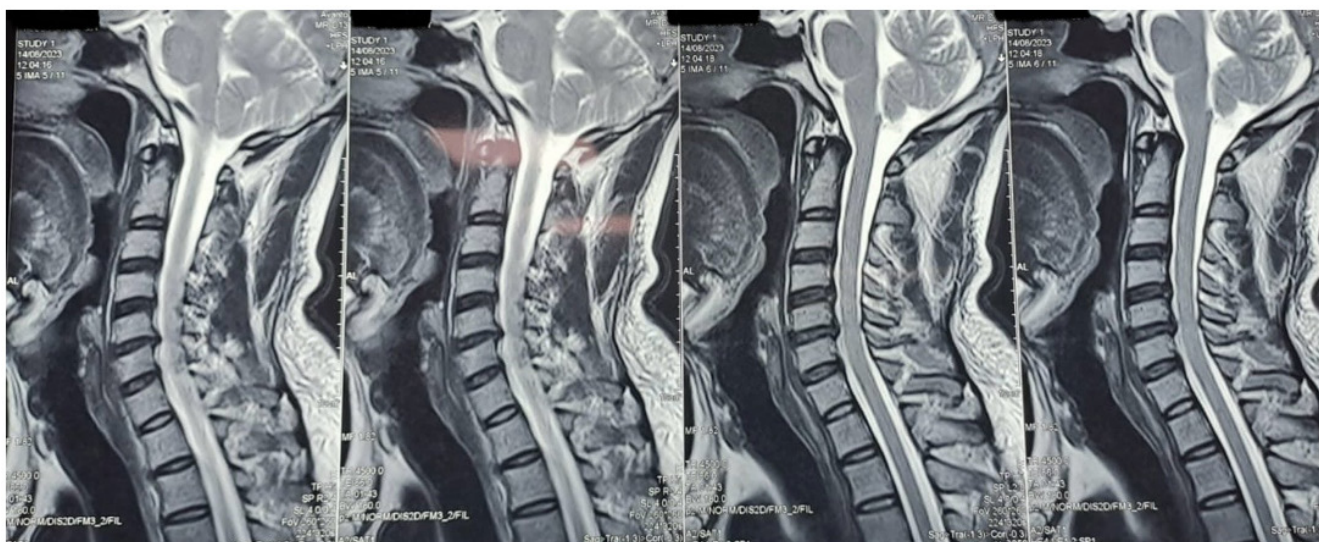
MRI performed to rule out spinal cord lesion.
